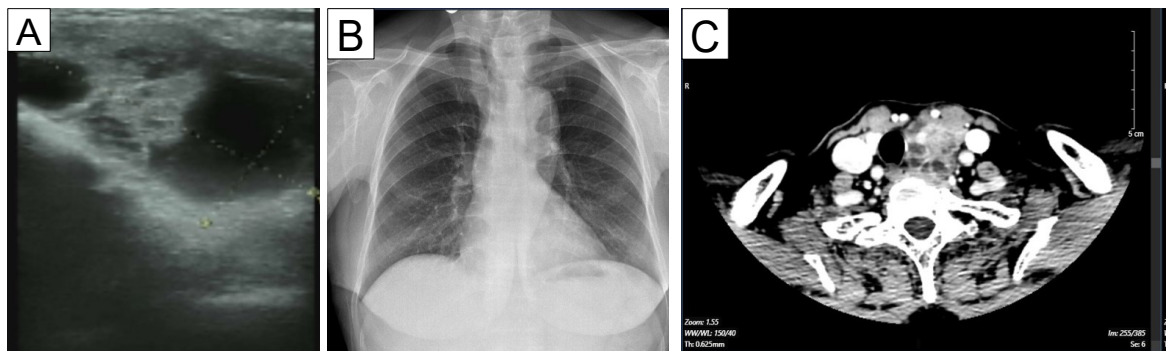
(A) Ultrasound image of the neck region. (B) Chest radiograph. (C) CT scan of the neck: an 4.8x3.9x4.0cm mass was found in the left lobe of the thyroid gland
